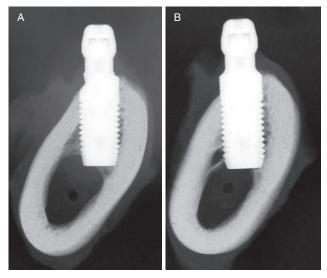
Buccal-lingual radiographs from test (A) and control (B) implants representing nonsubmerged sites obtained following biopsy procedures. Note the test implant design matching the sloped configuration of the alveolar ridge.
